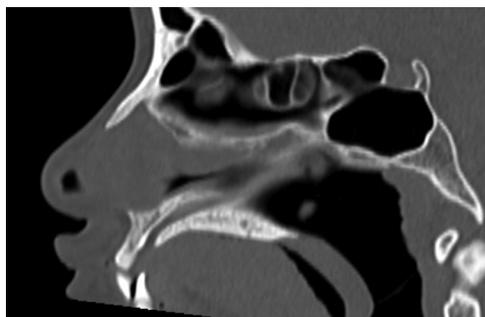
Sagittal CT slice in Binder's syndrome, with velo-premaxillary subduction.
